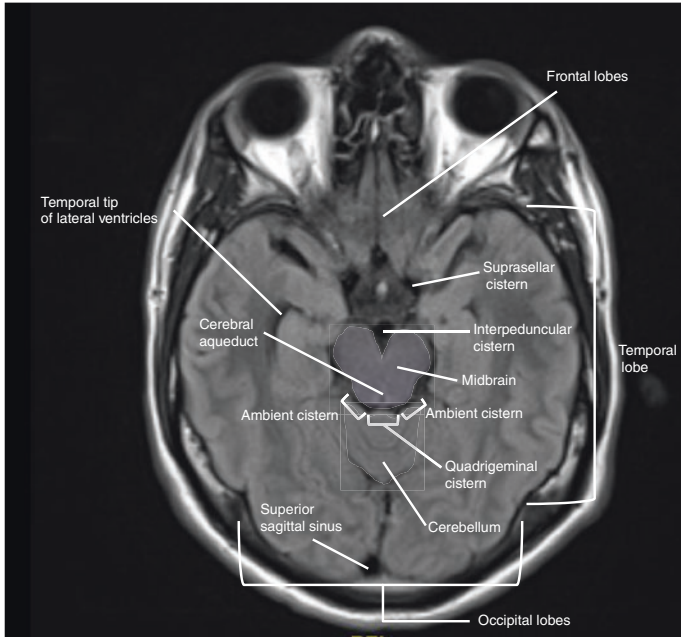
Midbrain and cisterns (Flair sequence MRI brain)
